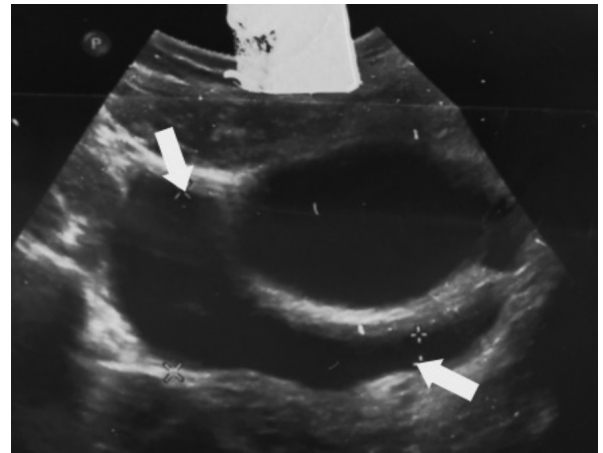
Abdominal ultrasound image – fluid in the pouch of Douglas
